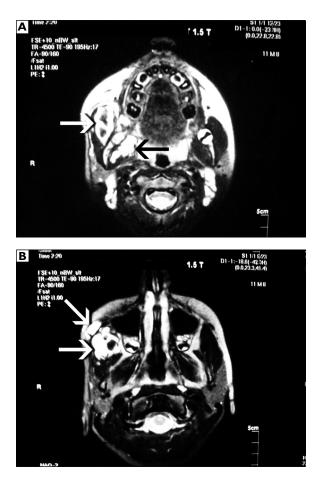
Contrast-enhanced axial T2-weighted MRI shows hyperintense masses in the right masseter muscle and in the neighbourhood of the medial part of the mass lesion in the masseter muscle with deep extension from the level of the ramus mandibula to the oropharynx and tonsil lodge (indicated with the arrows). B. Contrast-enhanced axial T2-weighted MRI showing hyperintense masses in the right masseter muscle and right infraorbital subcutaneous area (indicated with the arrows)
